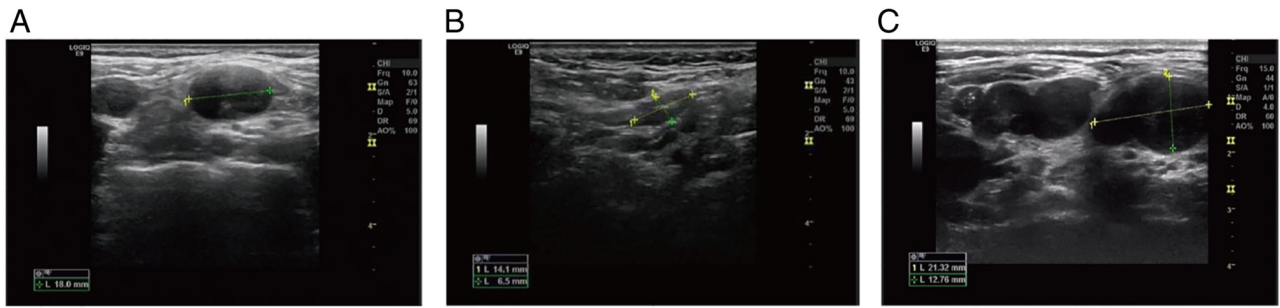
Ultrasound images of the patient. (A) Enlarged lymph nodes in the left neck in January 2017. (B) The cervical lymph nodes were reduced during therapy in January 2019. (C) The cervical lymph nodes were enlarged for the second time in March 2020.
